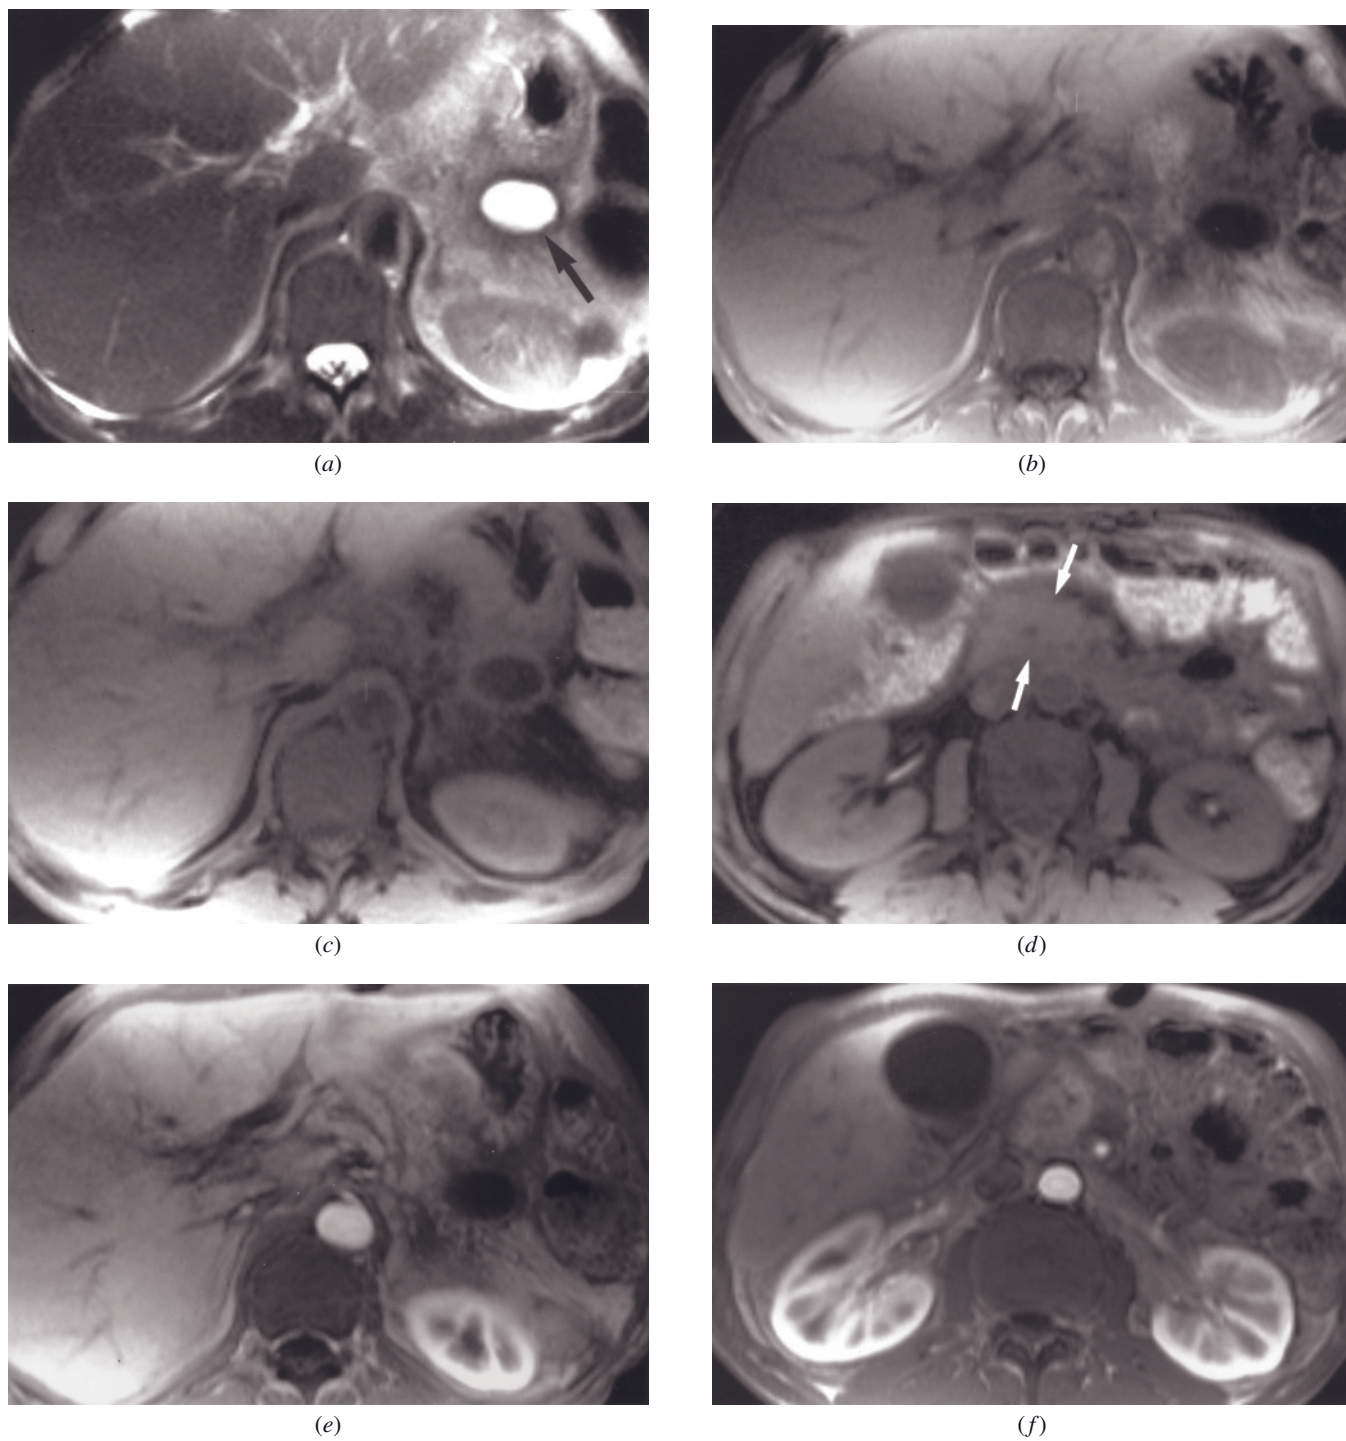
Acute on chronic pancreatitis with pseudocyst formation. T2-weighted SS-ETSE (a), T1-weighted SGE (b), T1-weighted fat-suppressed SGE (c, d), immediate postgadolinium T1-weighted SGE (e, f), and 90-s postgadolinium fat-suppressed
